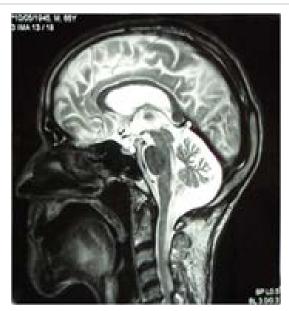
Sagittal Cerebral MRI (T₂ weighted): Cerebellar Atrophy.
